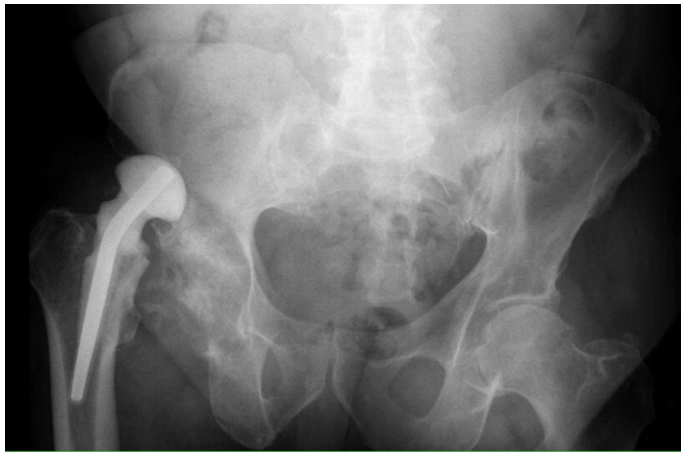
Dislocated antibiotic spacer. AP radiograph of the pelvis demonstrating posterior dislocation of the spacer relative to the acetabulum with no associated fracture evident.
